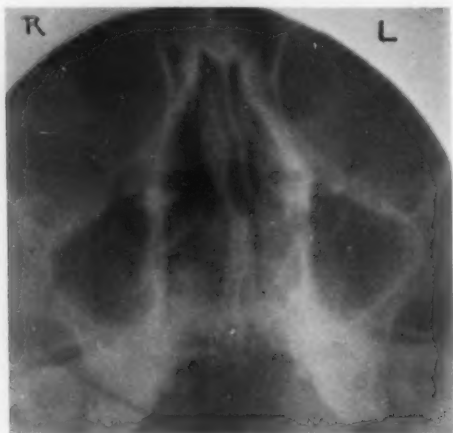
X-ray of the same patient. No marked difference between right and left side.
